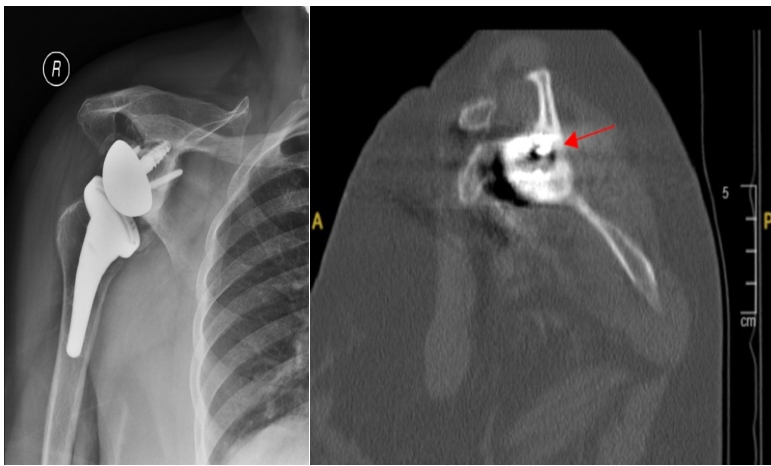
Anteroposterior radiograph of the right shoulder (left) showing loosening of the glenoid component, which was confirmed by a computed tomography scan of the right shoulder without contrast. The sagittal view, taken in November 2018 (approximately 3 years post- reverse total shoulder arthroplasty), demonstrates increased perihardware lucency around the glenoid component (arrow) (right).
